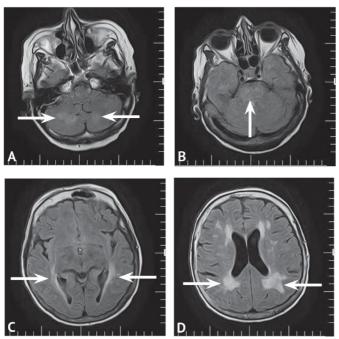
Magnetic resonance imaging of the brain in patient C. T2-FLAIR, axial sections: A — arrows indicate areas of increased signal in the white matter of the cerebellar hemispheres, specific for EPM; B — the arrow shows the high signal area in the brain pons (CPM); C, D — designated areas of high signal in the brain peduncles (EPM)
